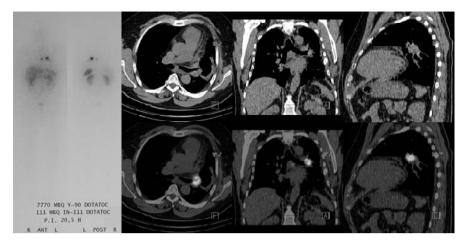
Patient with lung tumor. Irradiation with ¹¹¹In- / ⁹⁰Y-DOTATOC. Planar scintigraphic imaging on the left side, SPECT/CT fusion imaging on the right side of the picture.
